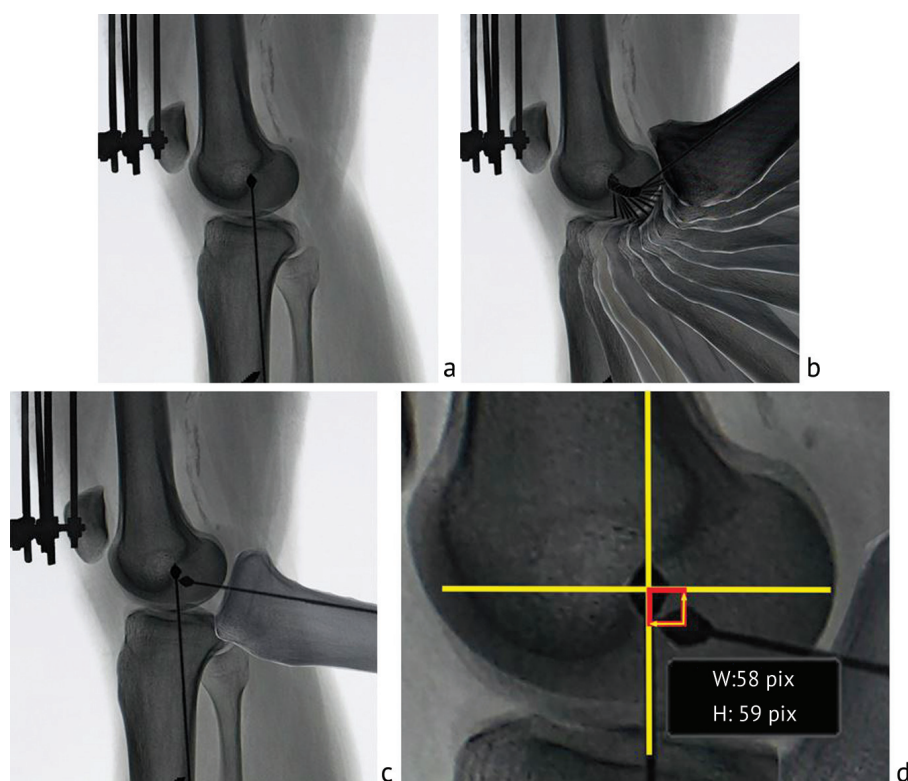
The experiment was performed by: (a) placing a mark at the point of intersection of the posterior cortical bone and the Blumensaat line; (b) staged radiographs adjusted with editing software; (c) radiograph of the knee flexed at 80°; (d) identifying the position of the mark under study relative to the mark located in the zero position
